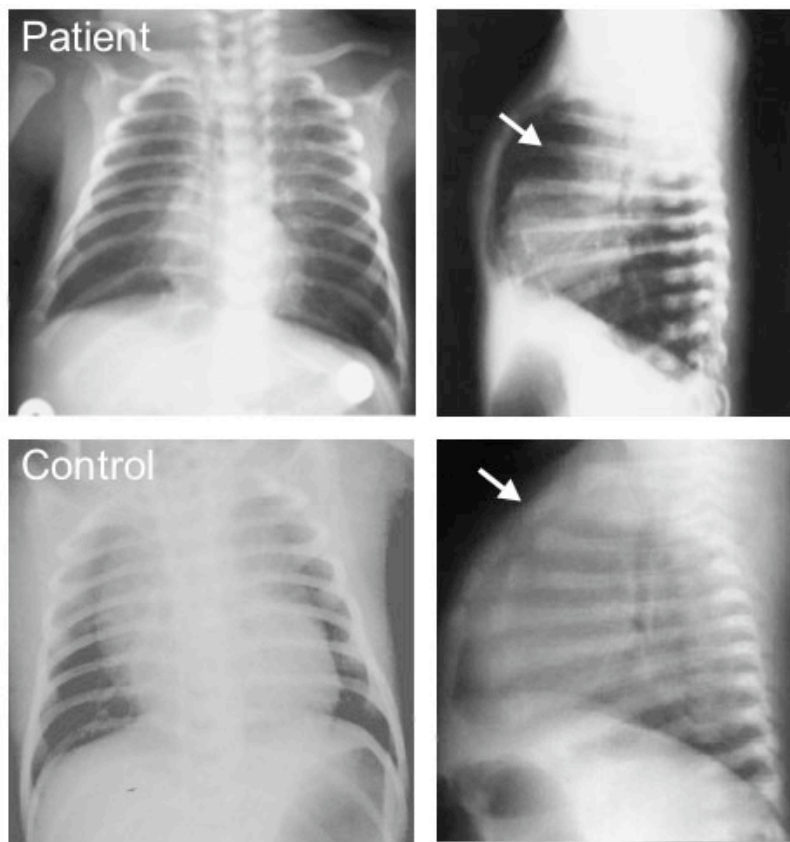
Chest X-ray (AP and lateral views) of patient and normal infant control. Arrows indicate border of heart shadow in patient (*upper right panel*) and thymic shadow in control (*lower right panel*).
